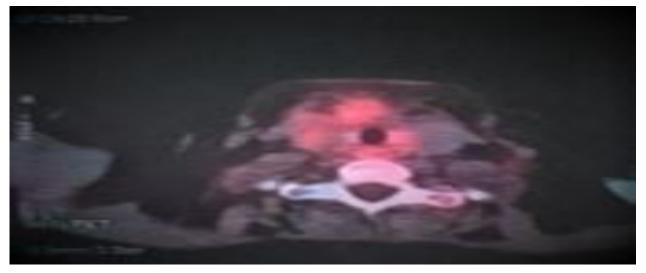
Baseline 18 FDG positron emission tomography image showing heterogeneous pathological hypermetabolism of the thyroid gland.
